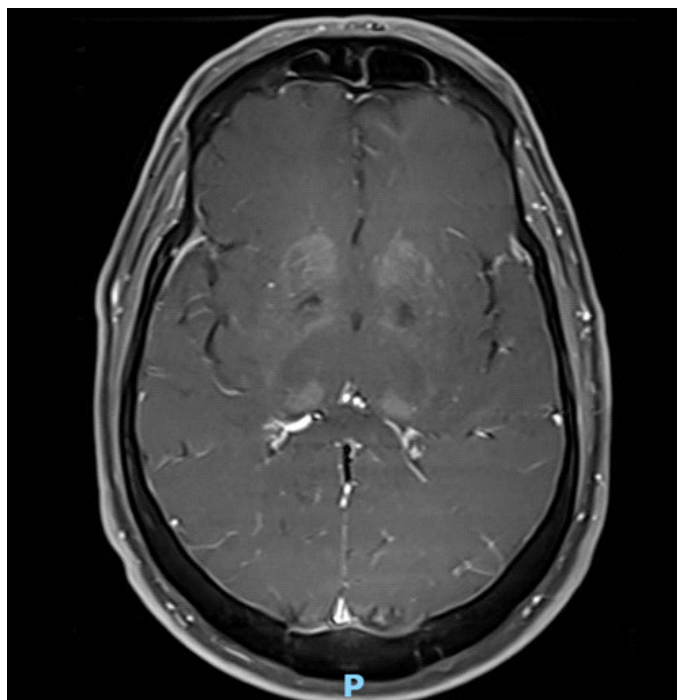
Axial gadolinium-enhanced brain MRI sequence.
